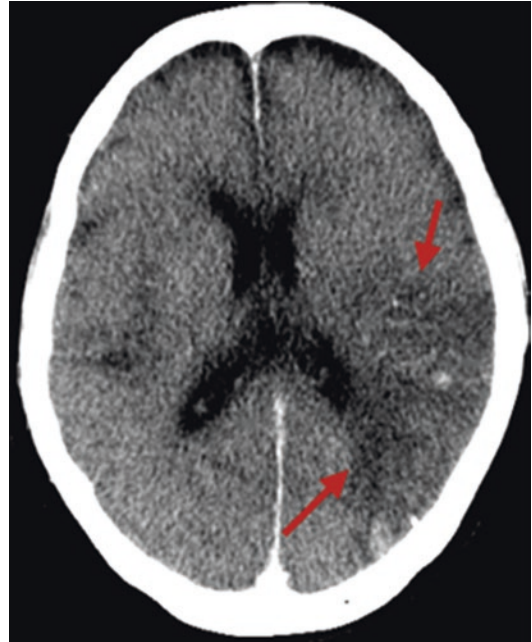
Axial brain computed tomography image of the cerebral infarction. A gray and white matter low-density area can be seen in the middle cerebral artery territory. Inside the area, small high-density regions are also seen, corresponding to hemorrhagic infarction
